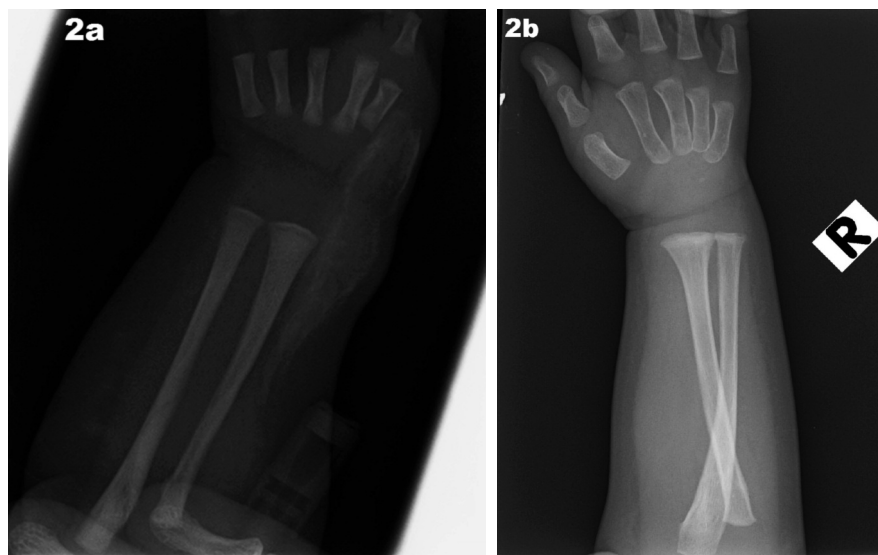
Plain radiography of right wrist showing zoning phenomenon of peripheral maturation (2a) and regression of lesion with time (2b).
